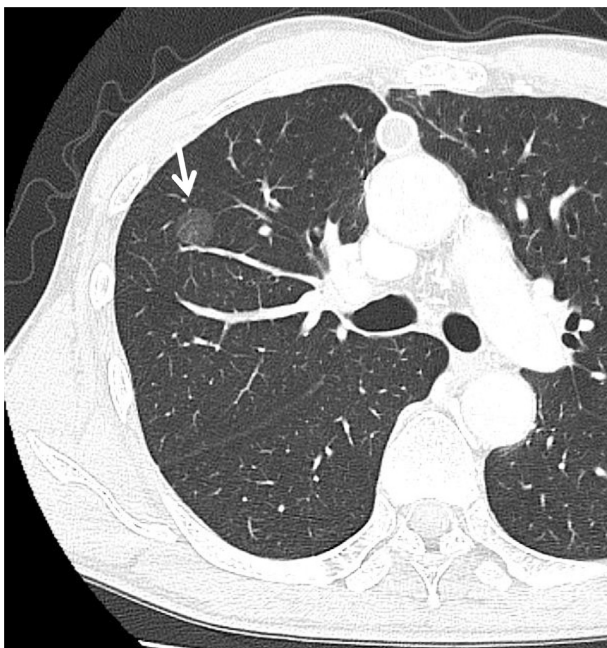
A high-resolution CT appearance of the representative case of focal pure ground-glass opacity (p-GGO) in this analysis (arrow head). The p-GGO lesions included in this analysis were well-circumscribed, spherical and without any areas of consolidation or cavities.
